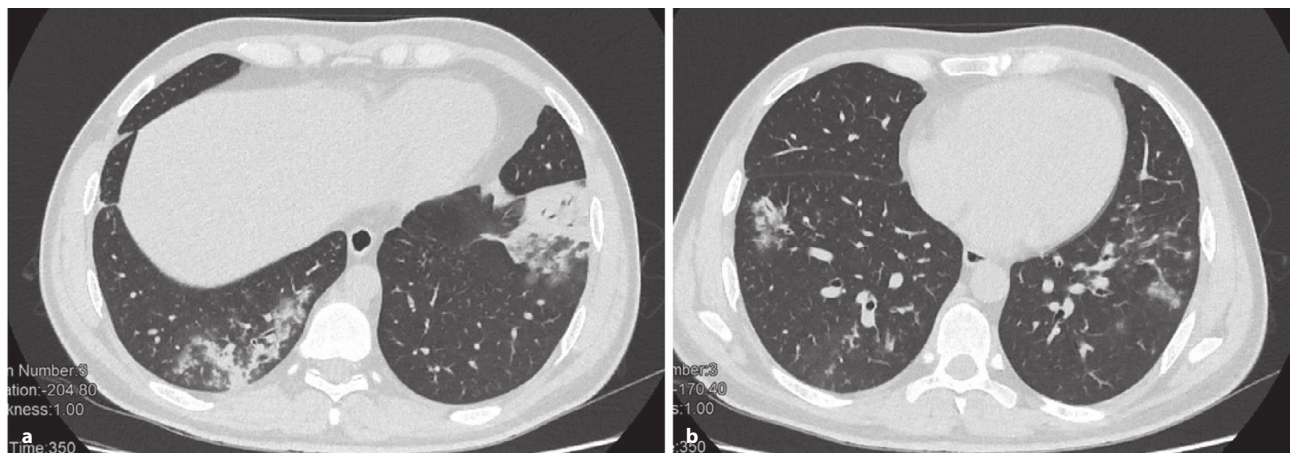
Chest computed tomography (CT) images revealed bilateral lower lobe bronchopneumonia with tree-in-bud pattern, peri-bronchial thickening, patchy distribution, ground glass opacities and left lobular opacity.
